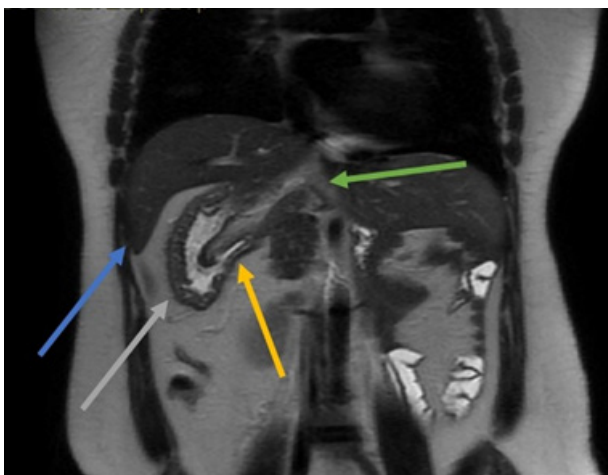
MRI in the coronal section of the T2 sequence showing usual hepatic parenchyma in the right abdomen (blue arrow), ectopic splenic tissue with splenosis (yellow arrow), gastric curvature in the right abdomen (gray arrow), and dorsal pancreas agenesis (green arrow).
